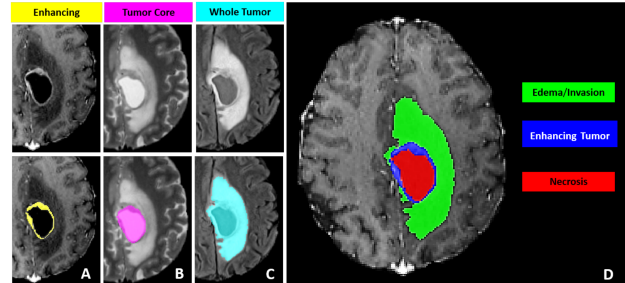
Glioma sub-regions considered in the RSNA-ASNR-MICCAI BraTS2021 challenge. A:T1ce, B:T2, C:T2-FLAIR. [2]
